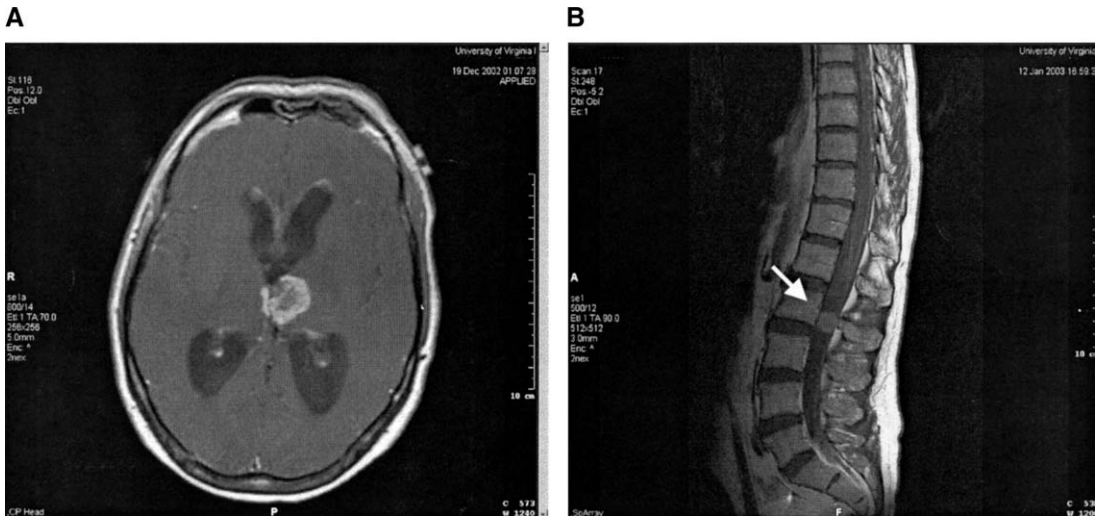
Grade III ependymoma. (A) Head MRI reveals ventricular dilatation and an intensely enhancing mass in the third ventricle on T1-weighted images after intravenous gadolinium administration. (B) The patient had evidence of spinal drop metastases at the time of diagnosis (arrow).
